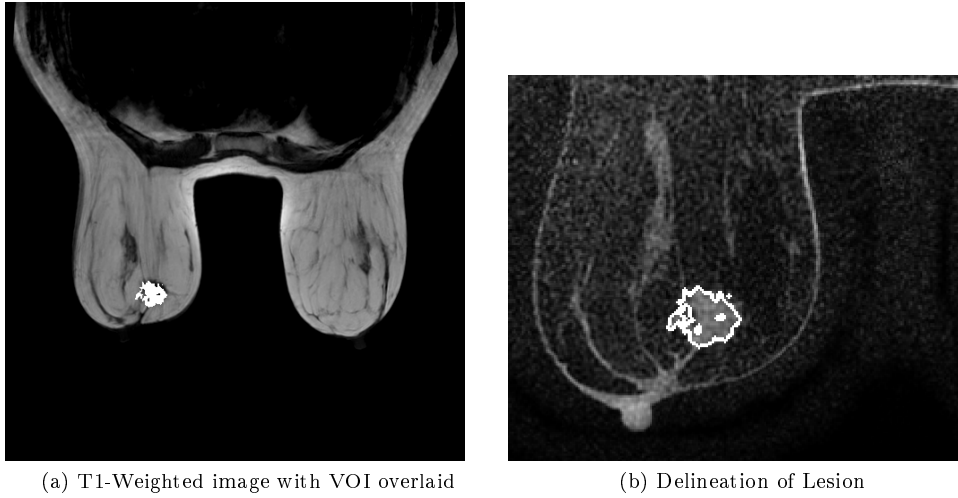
Typical lesion presentation with VOI overlays from both T1-weighted and first post-contrast images.
